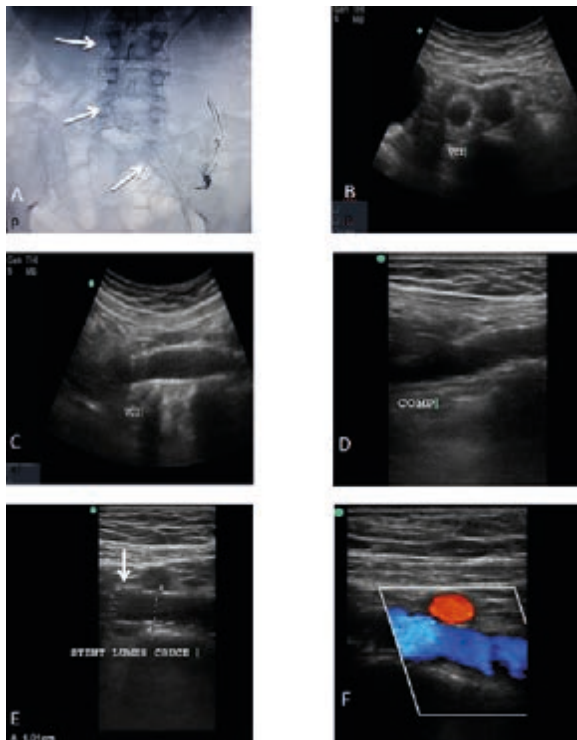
A) Post-PTA phlebography of a patient with MTS and ilio-caval stenting (white arrows). B) and C) Postoperative echo-Doppler, cross-sectional and longitudinal view of the stent proximal border at IVC level. D) Compression (COMP) is performed confirming partial collapse of the stentless IVC segment without changes in the stented segment, characteristic of the venous stent, where its radial strength prevents collapse thanks to the exertion of extrinsic compression. E) and F) Study with a 7.5 MHz linear transducer at iliac vascular crossing level showing the right primitive iliac artery (white arrow) on the left primitive iliac vein with the stent in its lumen, patent, and with a suitable caliber without any signs of compression.
